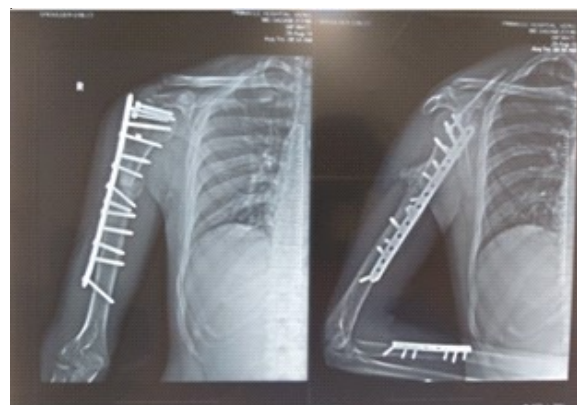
Eight months postoperative radiograph
